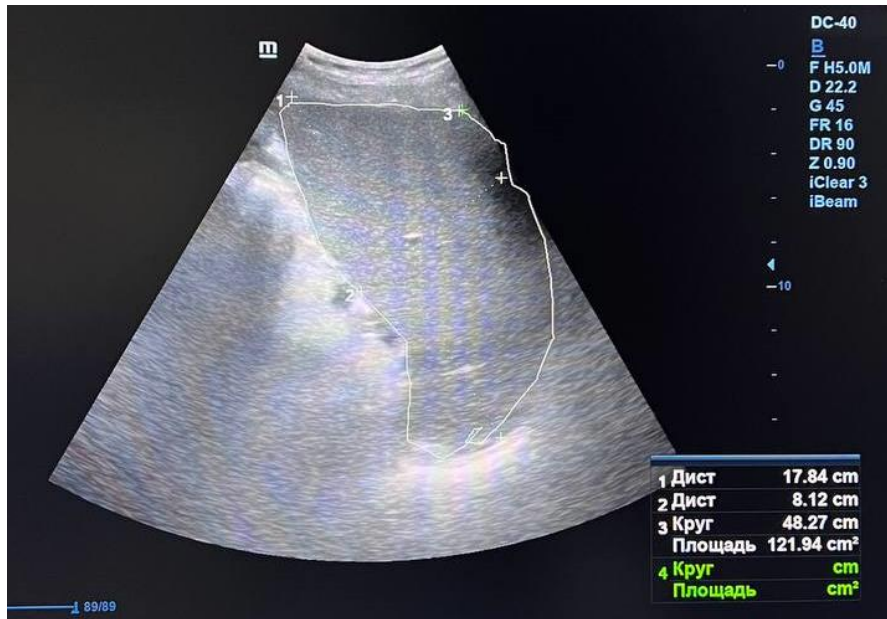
Reduction of the spleen size during dynamic ultrasound observation in 21 days after balloon angioplasty of the PVS.
